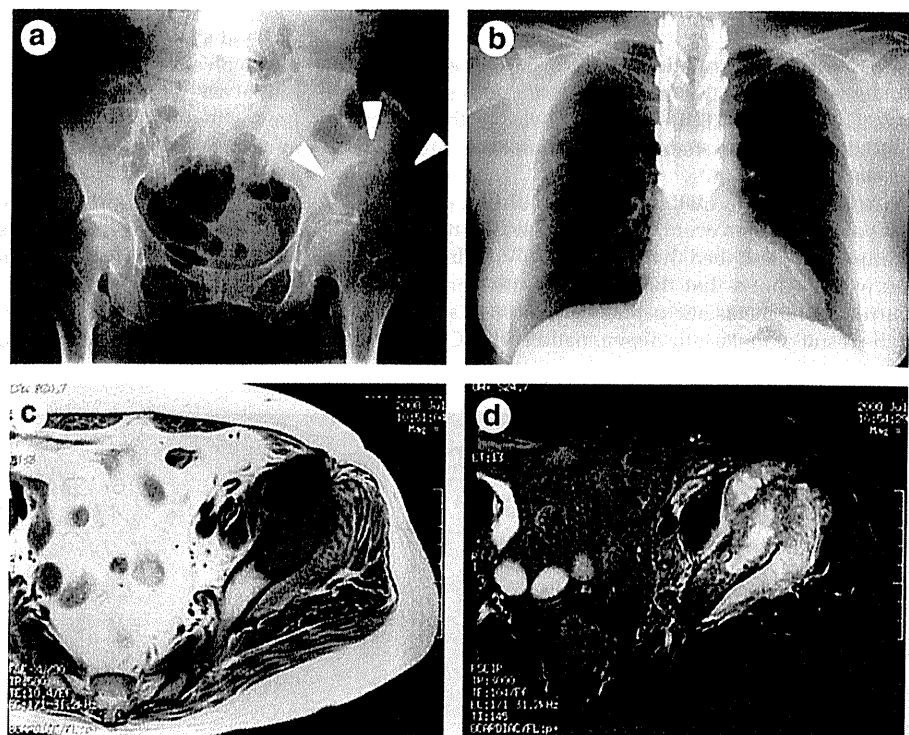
(a) A plain anteroposterior radiograph of the pelvis showing an osteolytic lesion in the left periacetabular region (arrowheads). (b) A plain chest X-ray at presentation showing no visible metastatic nodules in the lung. (c) An axial T1-weighted magnetic resonance image of the pelvis revealing a bone tumor in the left periacetabular region. (d) A short-tau inversion recovery image showing extensive edema in the surrounding soft tissue.
